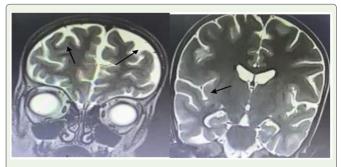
T2 FLAIR images at age 7 (AXIAL VEIW) Corpus callosal thinning and atrophy of the basal ganglia with prominent occipital horn of right lateral ventricles which denotes focal atrophy (marked by arrows).
